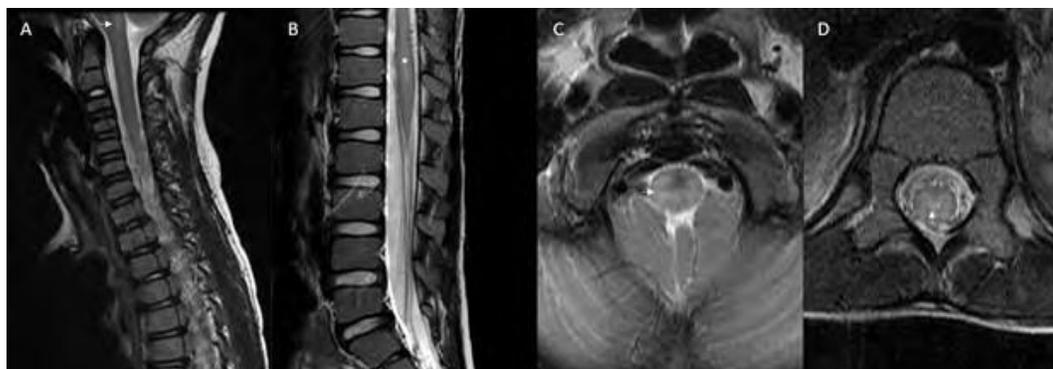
Full spine MR imaging on the first day of hospitalization. Sagittal T2-weighted image at the cervical spine level shows a subtle abnormal hyperintense signal (white arrow) at the cervicomedullary junction that continues in the medulla and the dorsal pons (A). Sagittal T2-weighted image at the level of conus medullaris shows central hyperintense signal abnormality (asterisk) (B). Axial T2-weighted image at the level of the medulla oblongata shows subtle abnormal hyperintense signals (white arrow) that are circumferential and dorsal in distribution (C). Axial T2-weighted image at the level of the conus medullaris shows central hyperintense signal abnormality (white arrow)(D). All abnormal hyperintense signals were not associated with pathologic contrast enhancement.
